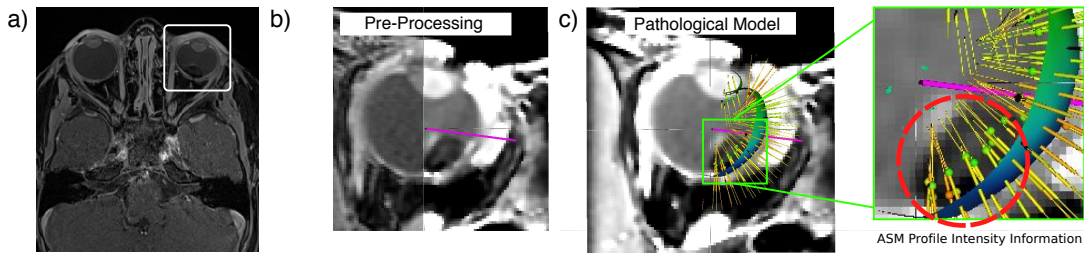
Learning a Pathological Eye Model (PM). We follow the steps in [2] to (a) automatically detect the eye in the 3D MRI, followed by a set of b) image pre-processing techniques to learn information of pathological and healthy structures jointly using c) intensity profiles containing pathological information.
